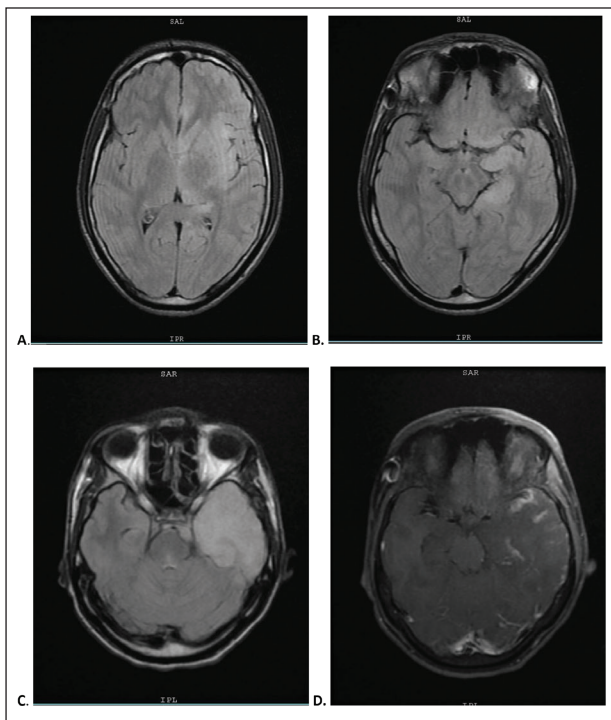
MRI brain on 1st admission: A. Axial FLAIR image reveals ill-defined band-shaped hyperintensity along the left insular cortex. No basal ganglia involvement is demonstrated, B. Axial FLAIR image shows thick gyral hyperintensity predominantly along the left medial temporal lobe. Repeat MRI brain done after 2 months of illness: C. Axial FLAIR image reveals confluent hyperintensity in the region of the left temporal lobe involving both grey and white matter, D. Axial post gadolinium T1 image shows multifocal leptomeningeal and gyral enhancement in the region of the left temporal lobe. A mild associated mass effect is also seen.
